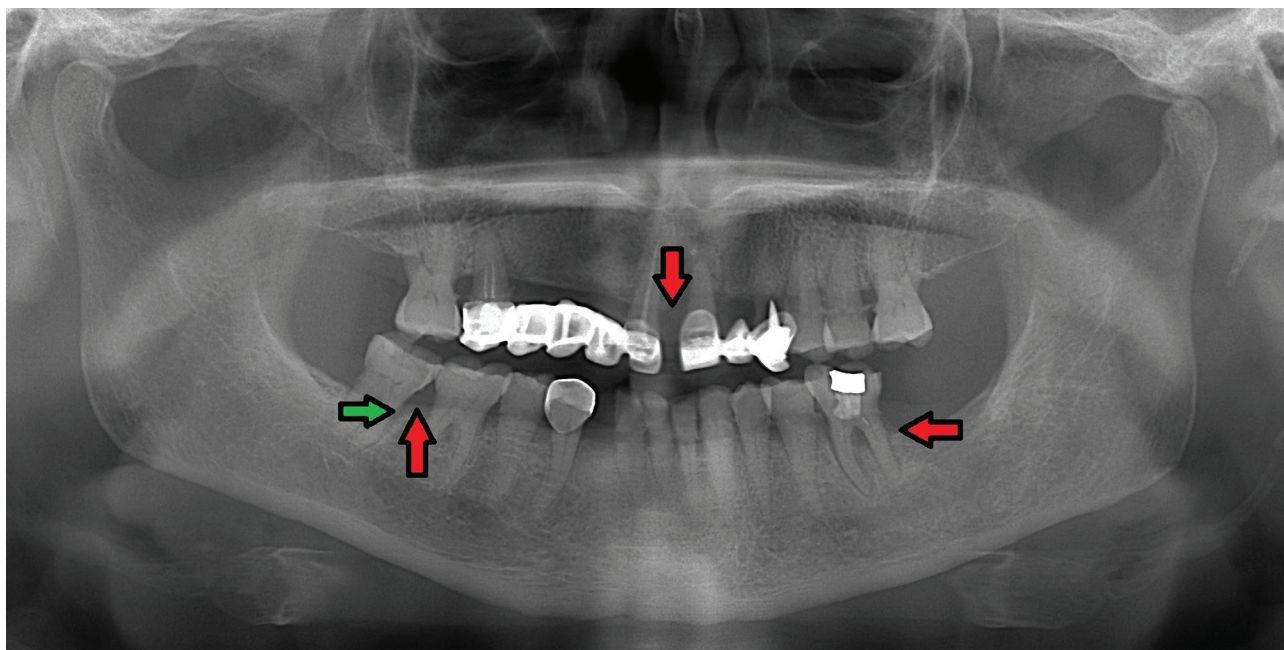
Orthopantomography (OPG) x-ray of a patient with DM and CKD. Bone resorptions are marked with arrows: horizontal (red color) and vertical – periodontal pocket (green color).
